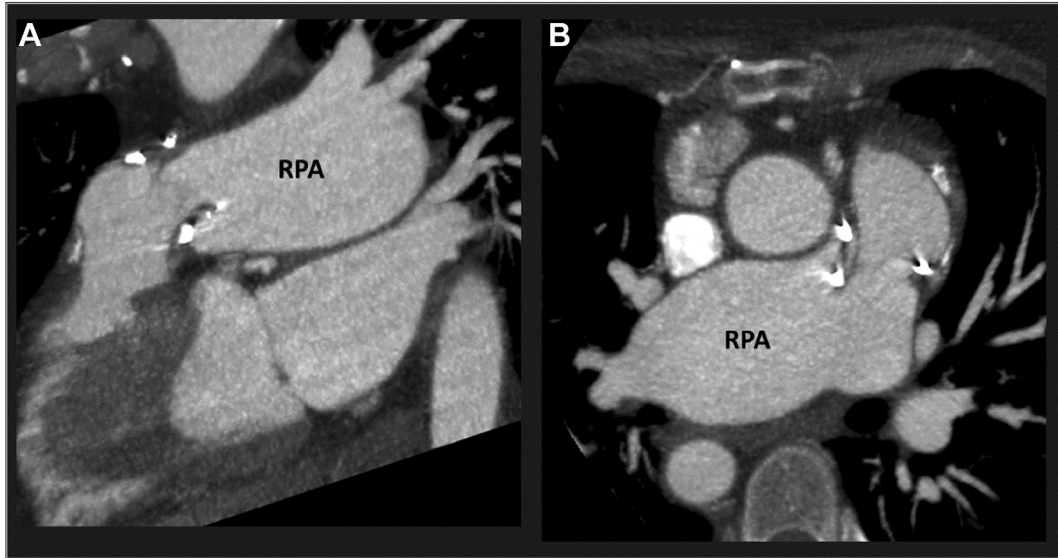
Example of a patient with tetralogy with absent pulmonary valve (after pulmonary valve replacement). (A) Sagittal oblique and (B) axial gated computed tomography images demonstrating a hugely enlarged right pulmonary artery (RPA). In this example, there was no major compression of any adjacent structures, but in some cases, there may be important dynamic compression of either the coronary arteries or adjacent airways, and evidence for this should be carefully sought.
